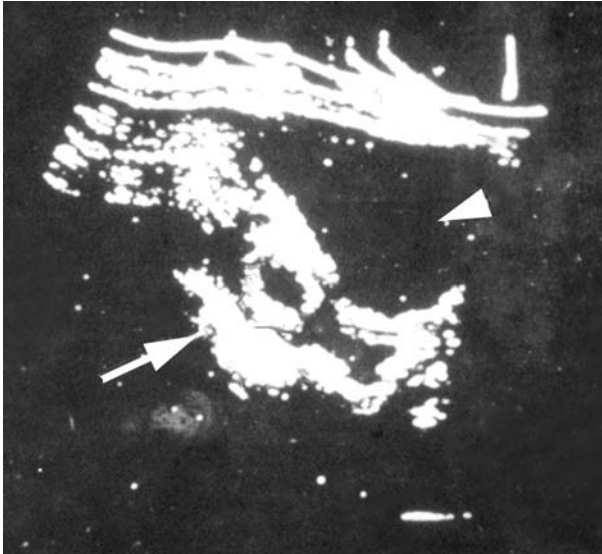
1963 ultrasound performed by Prof. Ian Donald, showing a fetus in utero (arrow) using the urinary bladder (arrowhead) as an acoustic window. Image courtesy of NHS Greater Glasgow and Clyde Archives.
